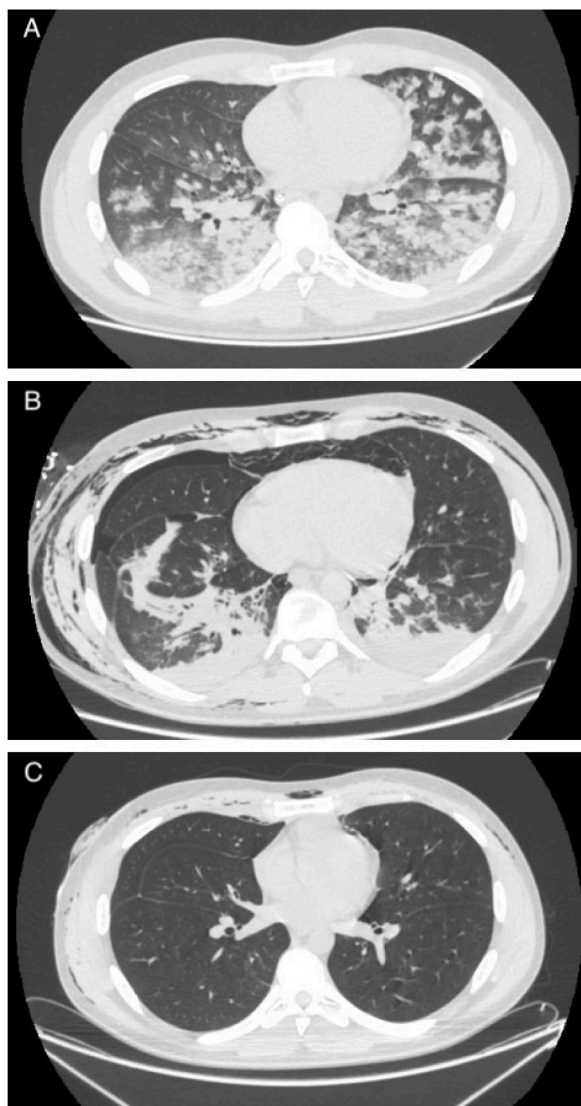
Progression of chest computed tomography. Panel A: Computed tomography on admission showed multiple patchy and coalescent areas corresponding to centrilobular micronodules in a tree-in-bud pattern, and discrete areas of ground glass opacities with compromise of both lung fields, especially in the inferior lobes. Panel B: Computed tomography five days from admission showed a significant decrease in multinodular opacities in comparison to the previous study, with persistence of centrilobular micronodules in a tree-in-bud pattern in the superior lobes and lingula. Residual anterior pneumothorax in the right hemithorax and extensive pneumomediastinum and subcutaneous emphysema. Panel C: Computed tomography thirteen days from admission showed complete resolution of ground glass opacities and centrilobular micronodules in comparison to previous studies, resolution of right pneumothorax, and significant decrease of pneumomediastinum and subcutaneous emphysema.
